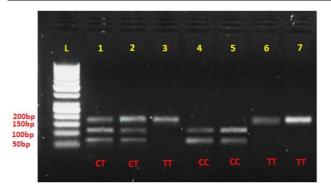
Gel electrophoresis of SLC30A8 variant on 2.5% agarose gel. Lane 1,2: CT, Lane 3,6,7: TT, Lane 4,5: CC: 125,56 bp; CT: 181,125,56 bp; TT: 181bp
